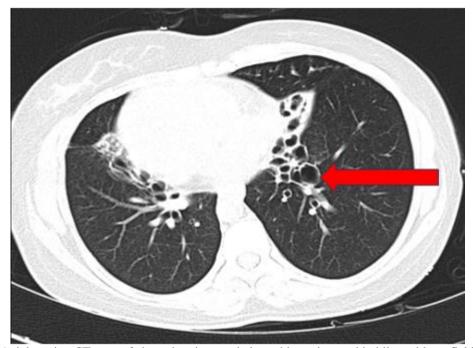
Axial section CT scan of chest showing cystic bronchiectasis noted in bilateral lung fields (arrow).
